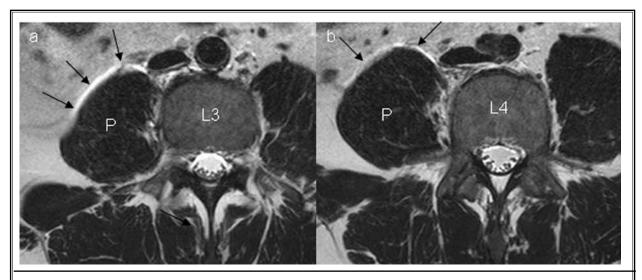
MRI: Transversal T2 weighted TSE at level L3 and L4 one day after the lumbar sympathetic neurolysis. Corresponding to Fig. 3 there is a small fluid film ventral and lateral the right psoas muscle. Arrows point to the fluid film. P = psoas muscle.
